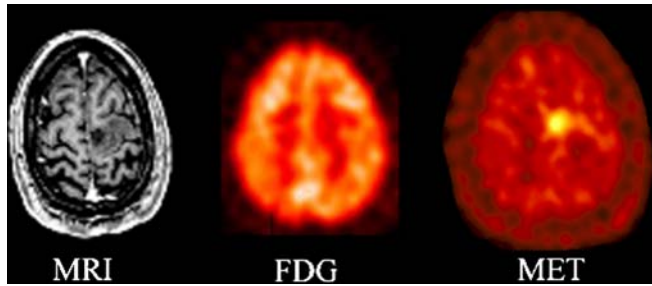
Grade II glioma. The contrast-enhanced T1-weighted MR, co-registered images of F-18 FDG and C-11 methionine in a proven case of grade II glioma. No contrast enhancement in MR and no FDG uptake but mild to moderate Met uptake in the same area.
